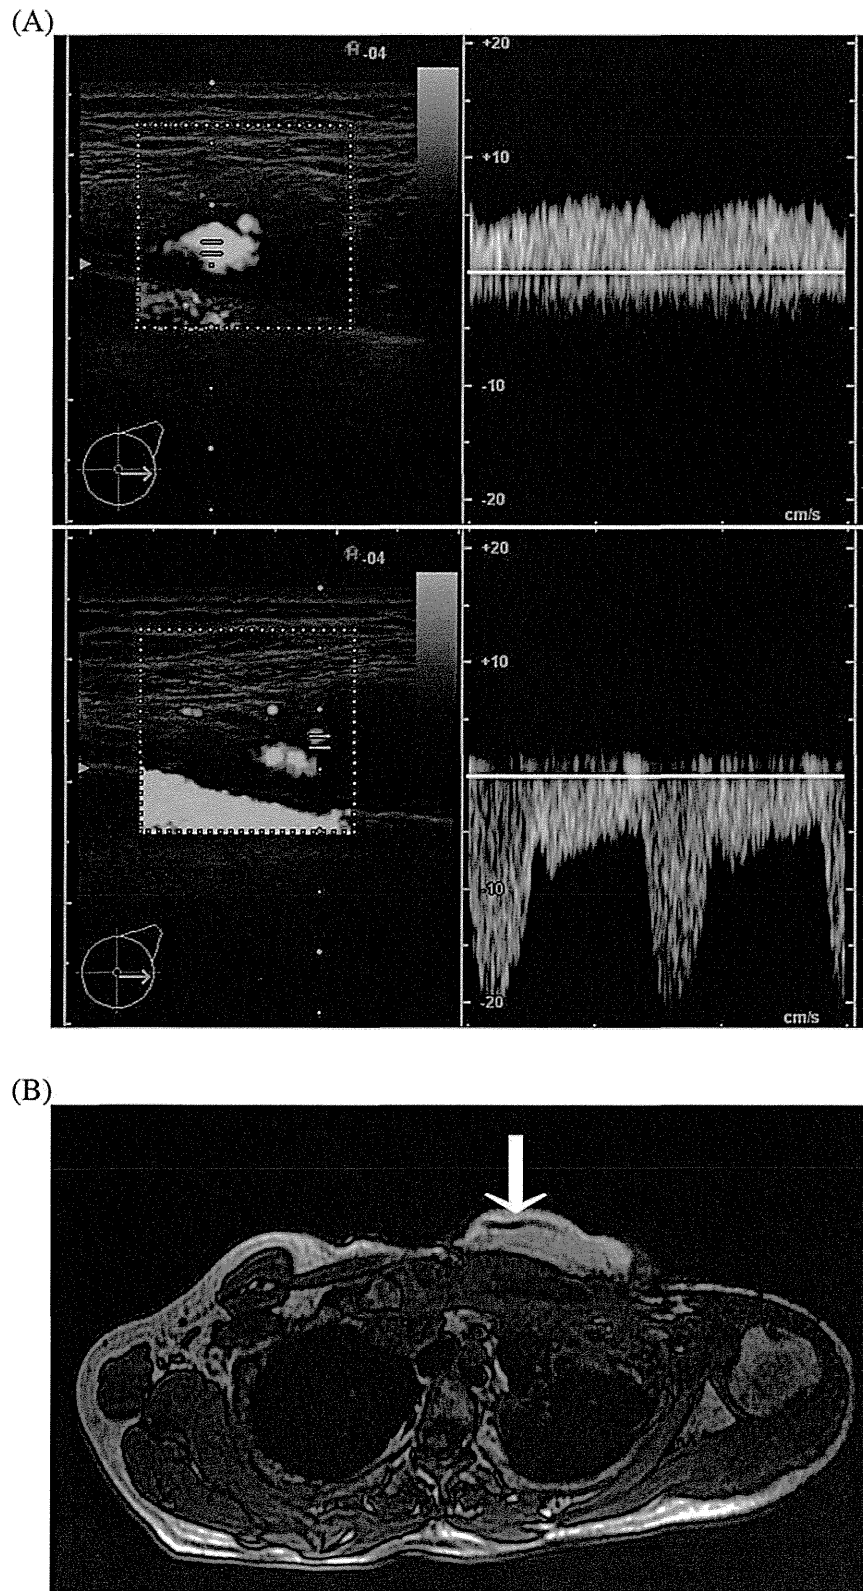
(A) Doppler spectrum of the DIEV (*above*) anastomosed to the antegrade IMV and the DIEA (*below*) six months post-operatively in patient 1. Doppler spectrum of the DIEV was opposite to that of the accompanying DIEA. This indicates that the flow direction is from the DIEV to the antegrade IMV. (B) Phase contrast two-dimensional magnetic resonance imaging six months postoperatively in patient 1. An arrow indicates a dilated SIEV anastomosed to the retrograde IMV running in the subcutaneous tissue of the flap. Parameter (not shown) indicates the direction of flow is from the SIEV to the retrograde IMV.
